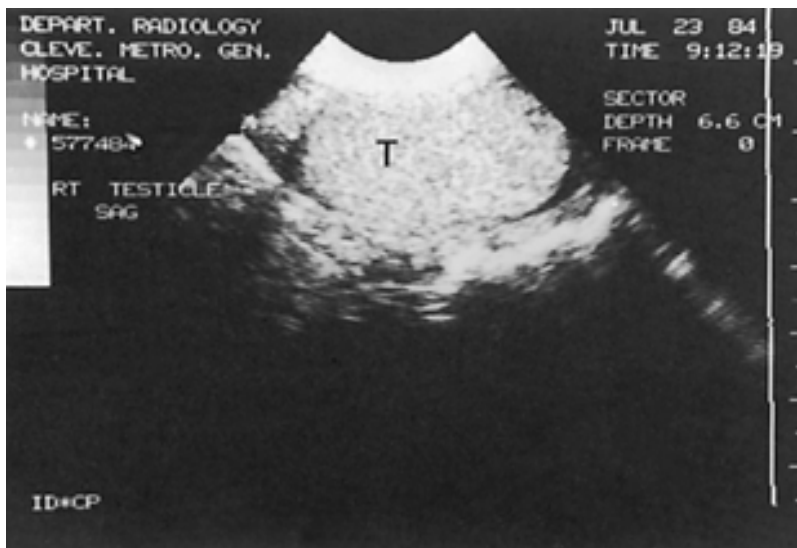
28. Scrotal ultrasound showing sonographic appearance of normal testicle (T).
